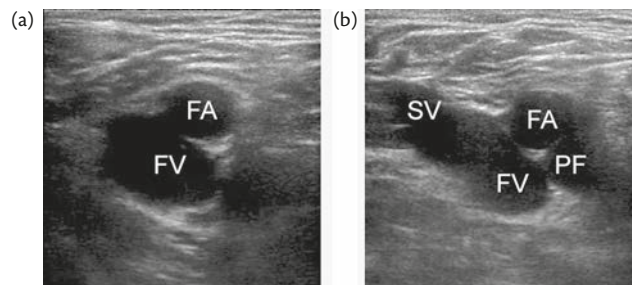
Ultrasound anatomy of the femoral region which may be complex and variable. Left side as viewed from below. (a) Vessels close to the inguinal ligament with common femoral artery (FA) partially overlying the femoral vein. (b) Lower in the groin the superficial artery (SFA) overlaps the FV and profunda femoral artery (PFA). The long saphenous vein (SV) is joining the FV.
